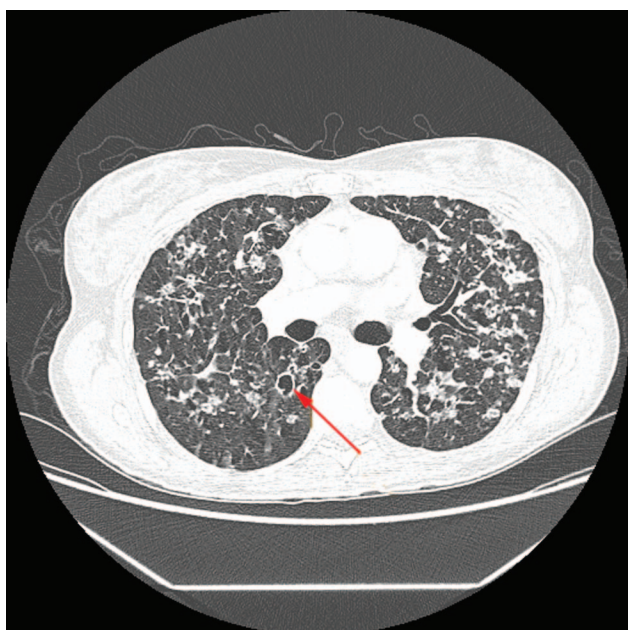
High-resolution computed tomography of the chest demonstrating cavitating nodules and focal bronchiectasis (arrow).
